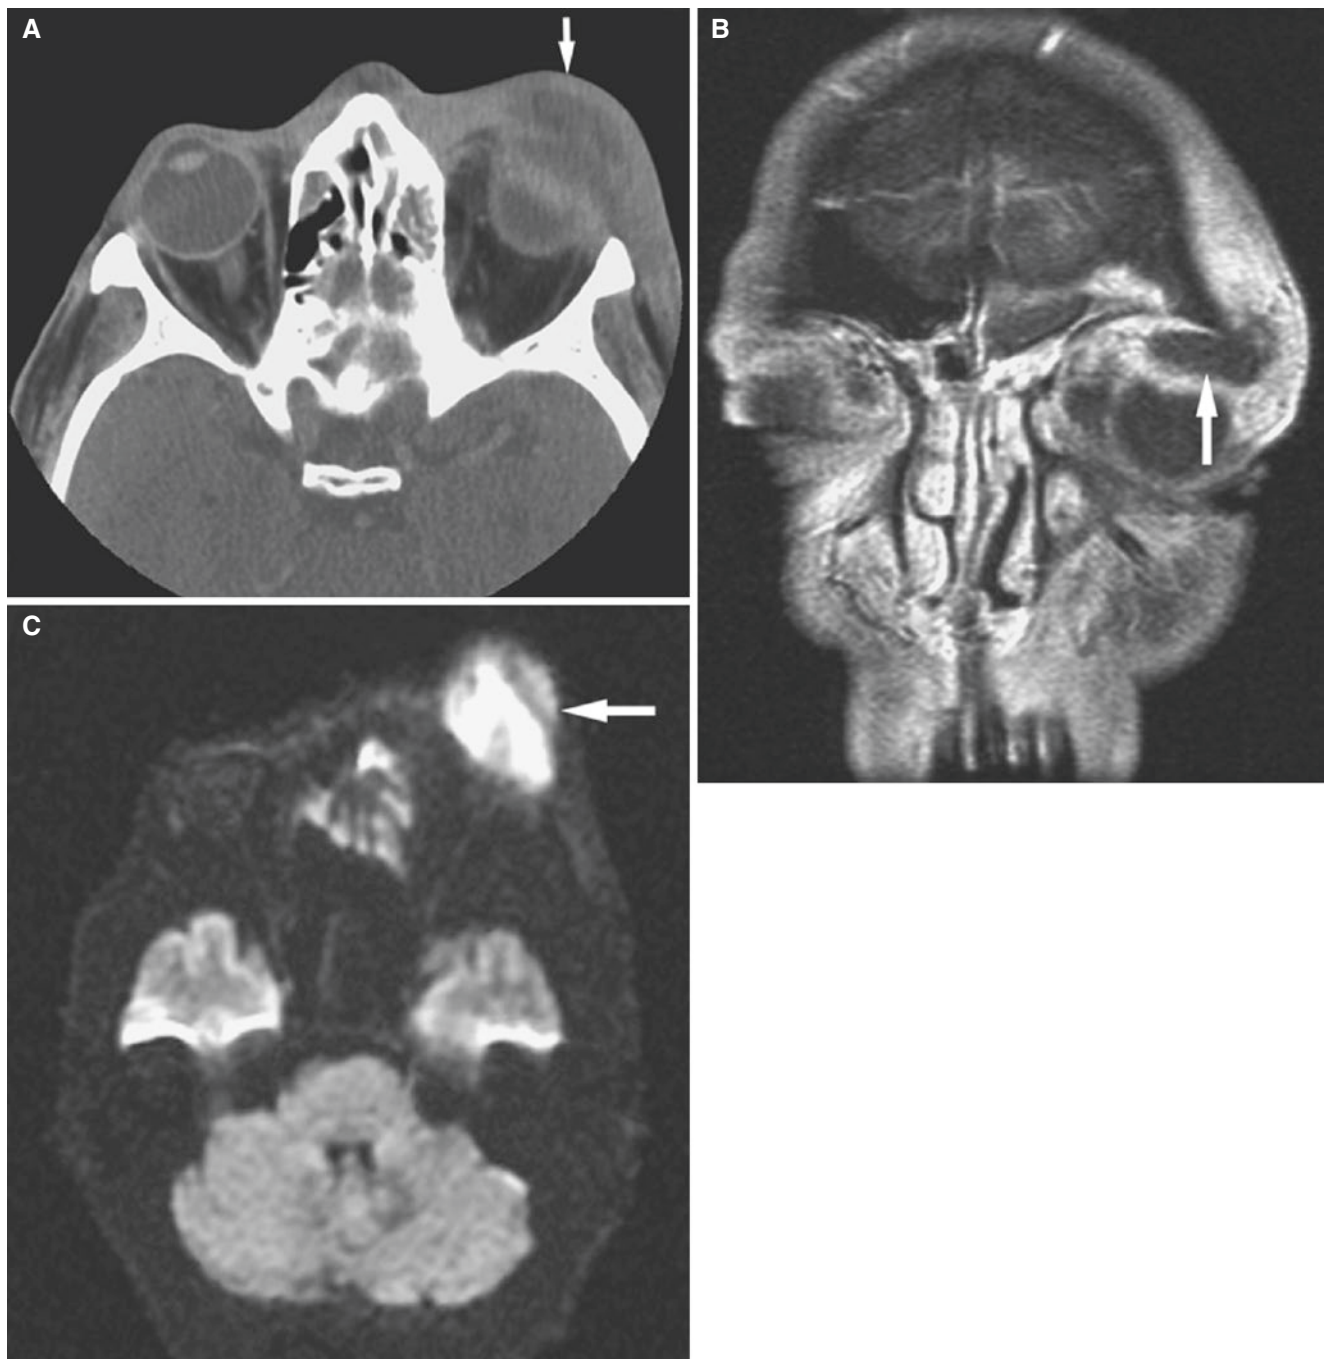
Orbital abscess; 26-year-old male with periorbital pain and swelling. (A) Axial post-contrast CT image demonstrates soft-tissue thickening and inflammatory changes in the left periorbital region with a rounded nonenhancing soft-tissue lesion in left upper eyelid (*arrow*) consistent with abscess. Mucosal thickening of ethmoid sinus is also present and may be the source of this abscess. (B) Coronal T1-weighted
